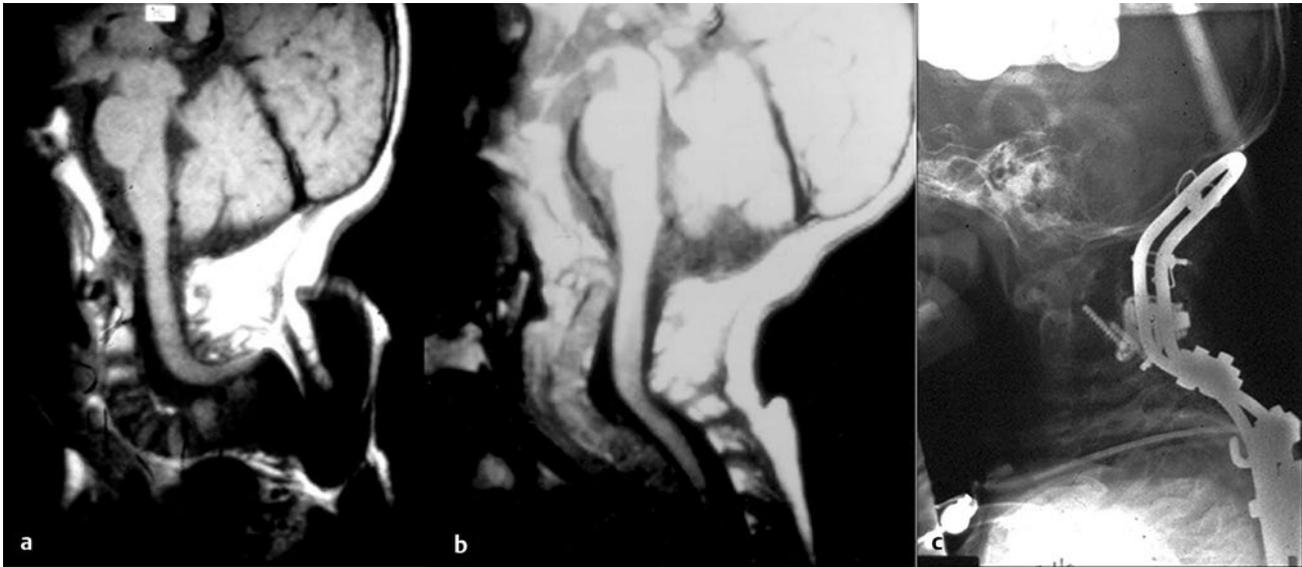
T1-weighted magnetic resonance images of the midsagittal cervical spine (a) before traction and (b) after traction demonstrate significant reduction in an 8-year-old boy with severe progressive swan neck deformity due to Larsen syndrome. (c) Postoperative lateral radiograph demonstrates the instrumentation used in successful fusion.
